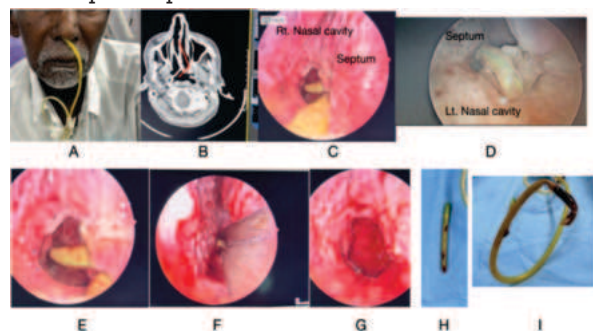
A - Impacted tube at the time of presentation ; B - CT showing the impacted foreign body traced parallel to the red line marked ; C - Ryle's tube piercing the right side of septum ; D - Tube kinked in left nasal cavity and re-piercing the septum ; E - Re-entering the right nasal cavity and impinging on Rosenmuller's fossa with tip not being visualised ; F - kinked portion being cut with turbinectomy scissors ; G - Right nasal cavity post tube removal ; H & I - Removed portions of the tube showing the impinged portion and the kinked part respectively
